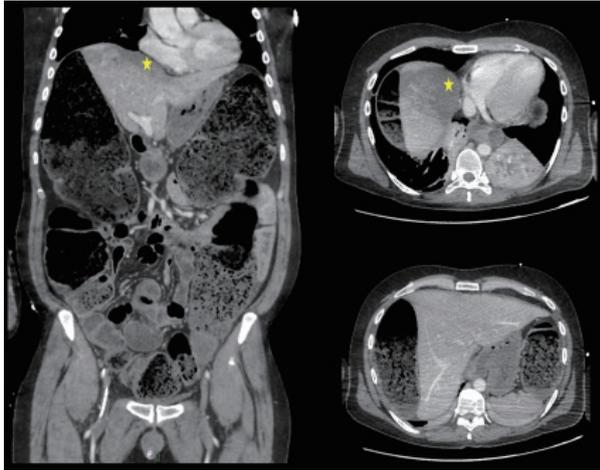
Computed tomography revealed the presence of a giant fecaloma causing hepatic venous outflow obstruction by extrinsic compression (yellow star indicates the areas of liver congestion).
